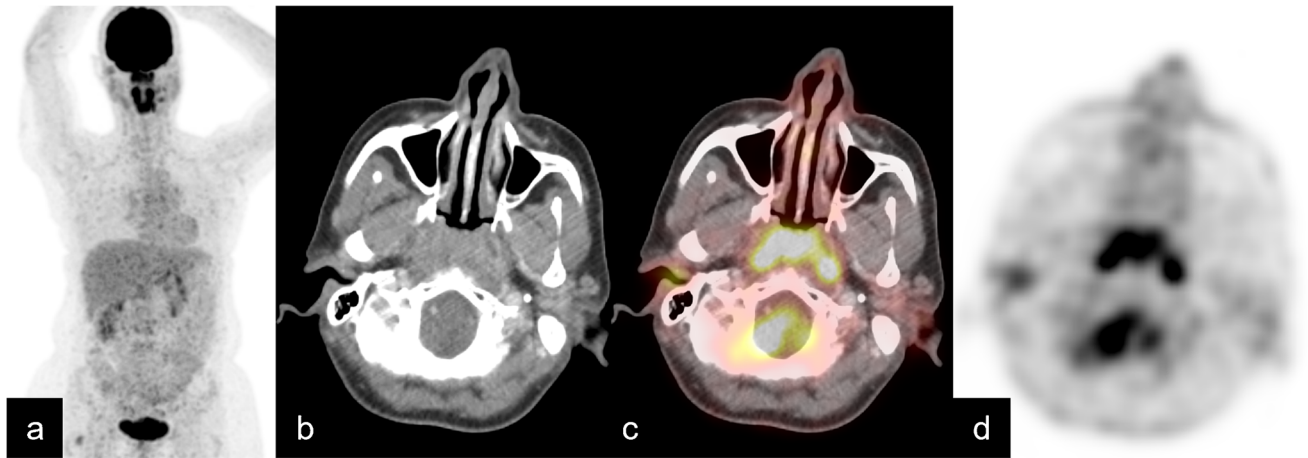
A representative case FDG-avid ENMZL. A 50-year-old woman with a biopsy-proven, advanced-stage, ENMZL of the nasopharynx. Ki 67 index was 5%, and LDH level was 425. Predicted SUVmax = $-2.745 + 1.86 [1] + 0.123 [5] + 0.009 [425] + 1.92$
